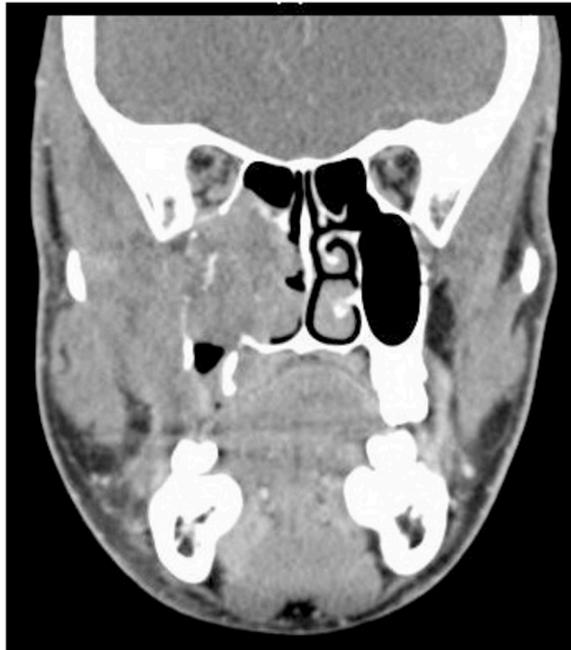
CT neck with contrast soft tissue window, coronal cut, showed soft tissue mass in left maxillary sinus and masticator involving the pterygoid plates, maxillary sinus walls, pterygoid fossa, Vidian canal, and foramen rotundum.
